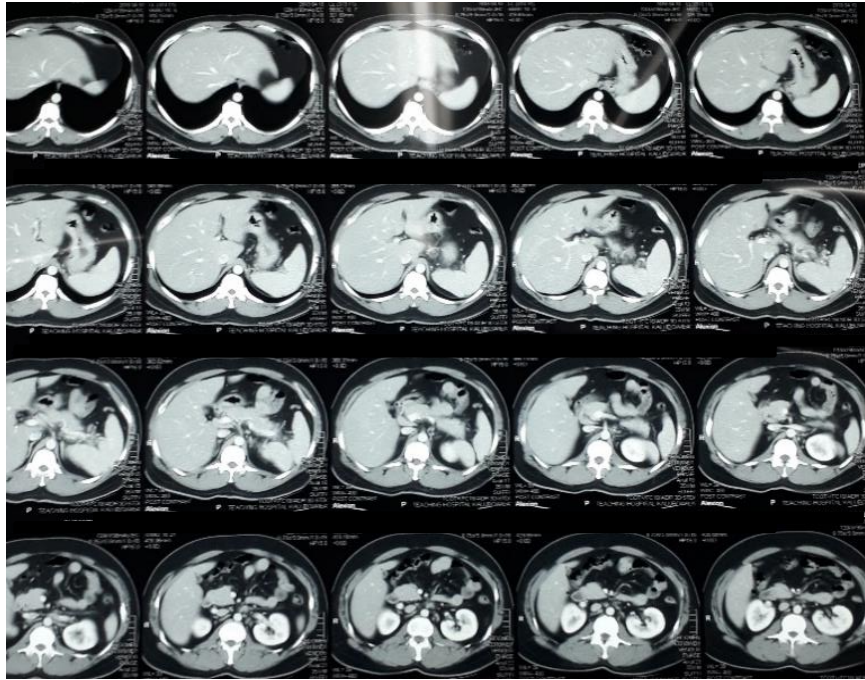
Contrast-enhanced computed tomography (CECT) of chest, abdomen and pelvis showed focal areas of bronchiectasis with small cavities in the left upper lobe of lung with multiple small lymph nodes seen in cervical, mediastinal and paraaortic areas. There were multiple small cavities in both lobes of the liver. But there was no other collection /abscess seen in neck, chest, abdomen or pelvis
